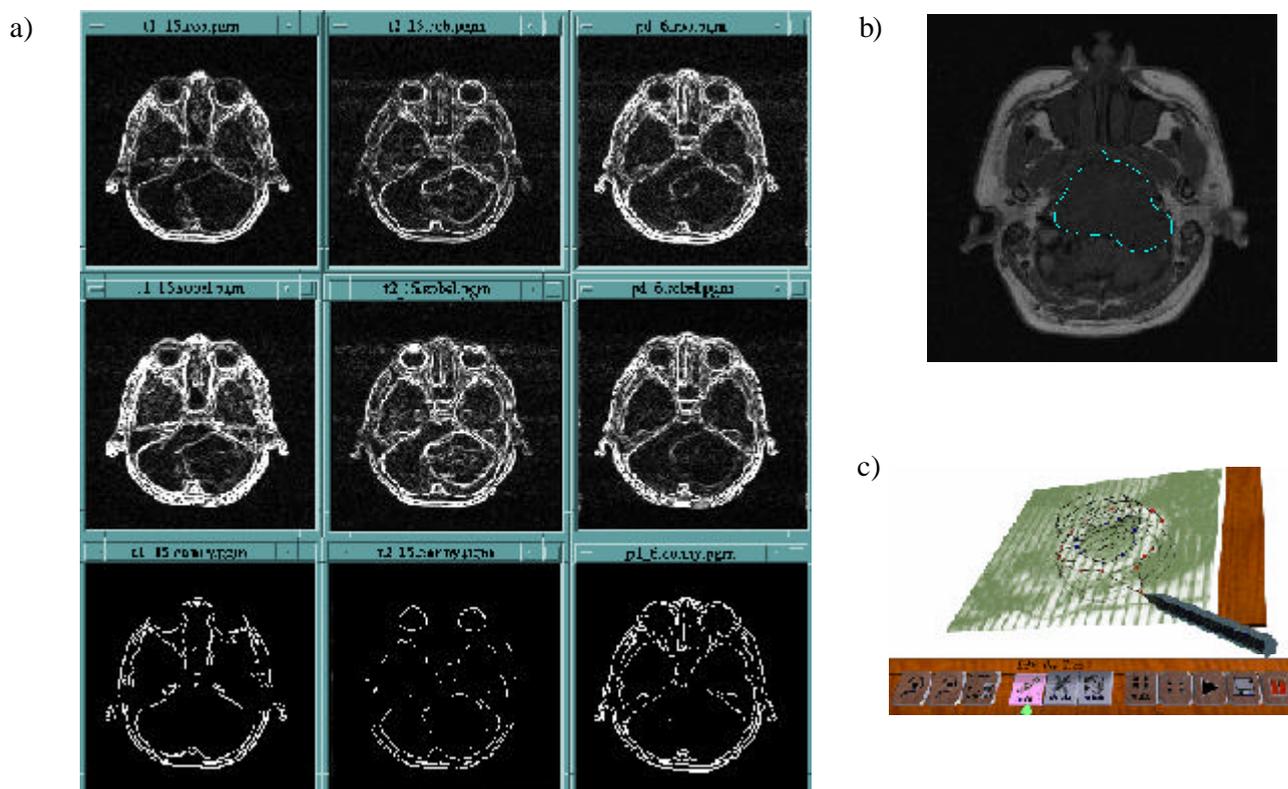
Image-based and interactive segmentation of medical images: a) edge detection of T1-, T2-, and PD-weighted MR images using three different edge detectors: Roberts, Sobel, and Canny; note that none of them is able to delineate the tumor completely; b) interactive segmentation of a brain tumor in a 2D case; c) interactive segmentation in a 3D case by using a customized 3D contour editor.
